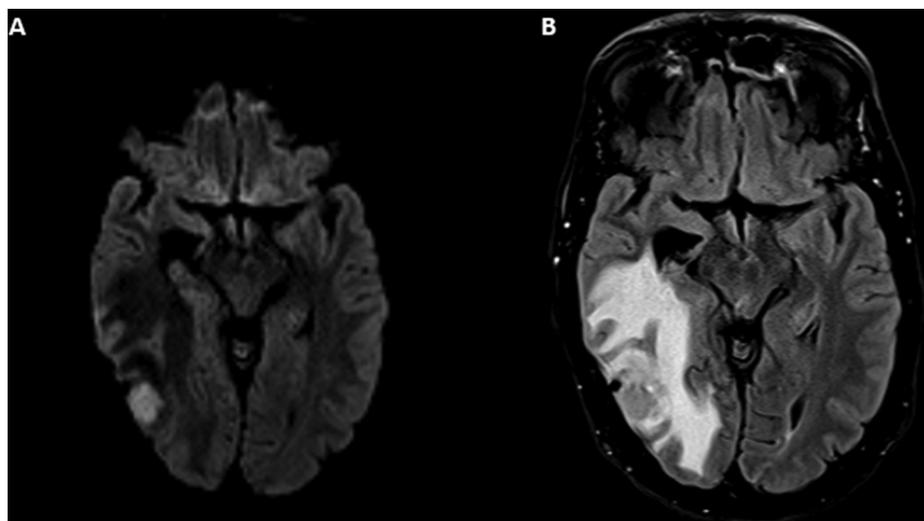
A. Axial diffusion weighted MRI. B. T2 weighted MRI with contrast: area of restricted diffusion in occipitotemporal lobe with vasogenic edema.
